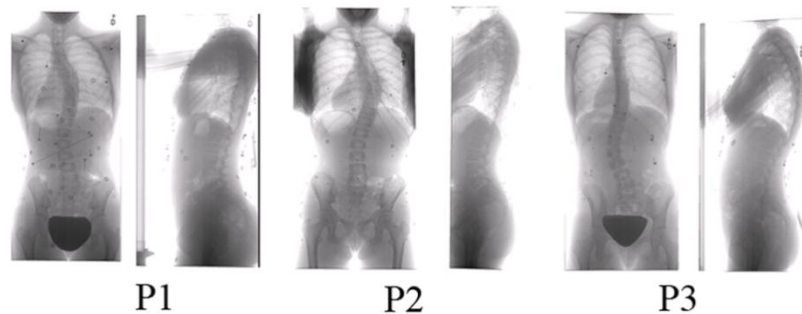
Article 4 Figure 2: Postero-anterior and lateral radiographs of the patients
